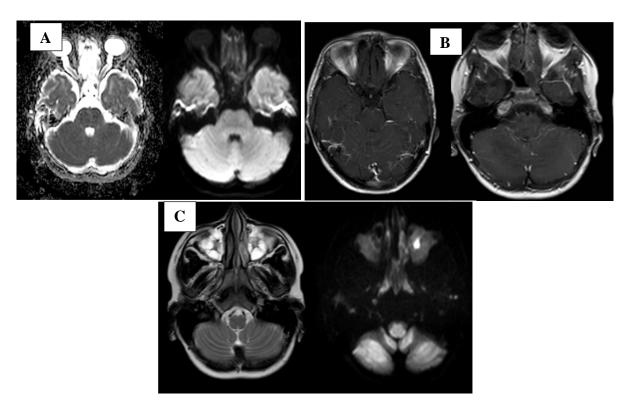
Magnetic resonant imaging (MRI) brain of case 2. A: DW restriction affects both optic nerves. B: Mild accentuated leptomeningeal enhancement along posterior fossa especially cerebellar fossa and to lesser degree cerebral hemispheres. C: bilateral ethmoid, maxillary and sphenoid sinusitis with left maxillary central DW restricted focus suggestive of pus locule
